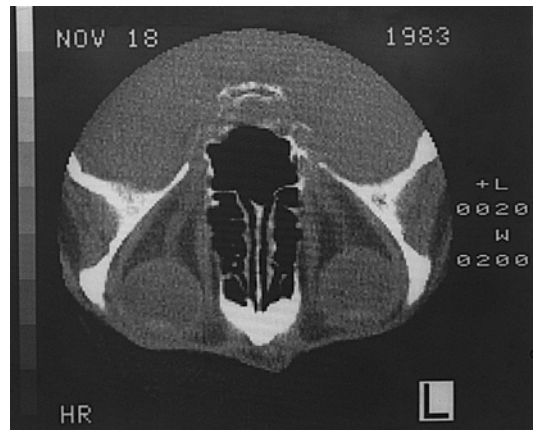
Computed tomography (CT) scan of eyes and orbit (normal)
